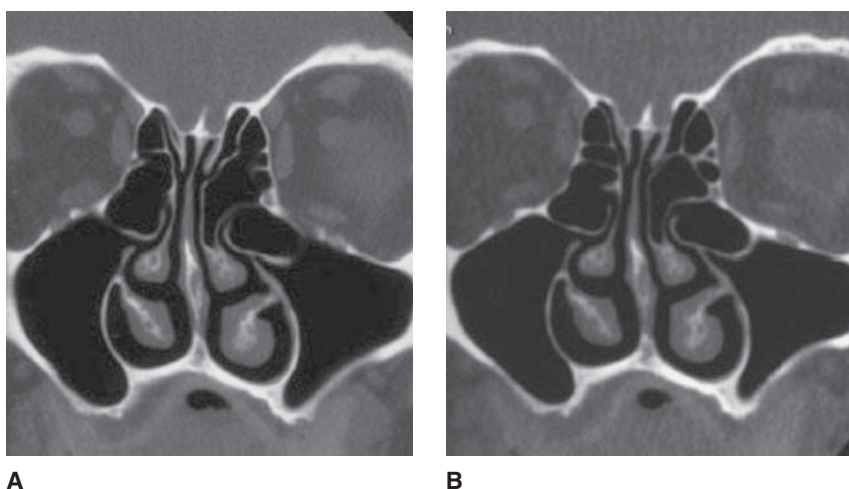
Standard-dose. (A) compared to low-dose (B) computed tomography images of normal ethmoid and maxillary sinuses obtained in a coronal plane through the ostiomeatal complex. (Reproduced, with permission, from Hagtvedt T, Aalokken TM, Notthellen J, et al. A new low-dose CT examination compared with standard-dose CT in the diagnosis of acute sinusitis. *Eur Radiol.* 2003;13:976–980. With kind permission from Springer Science and Business Media.)
